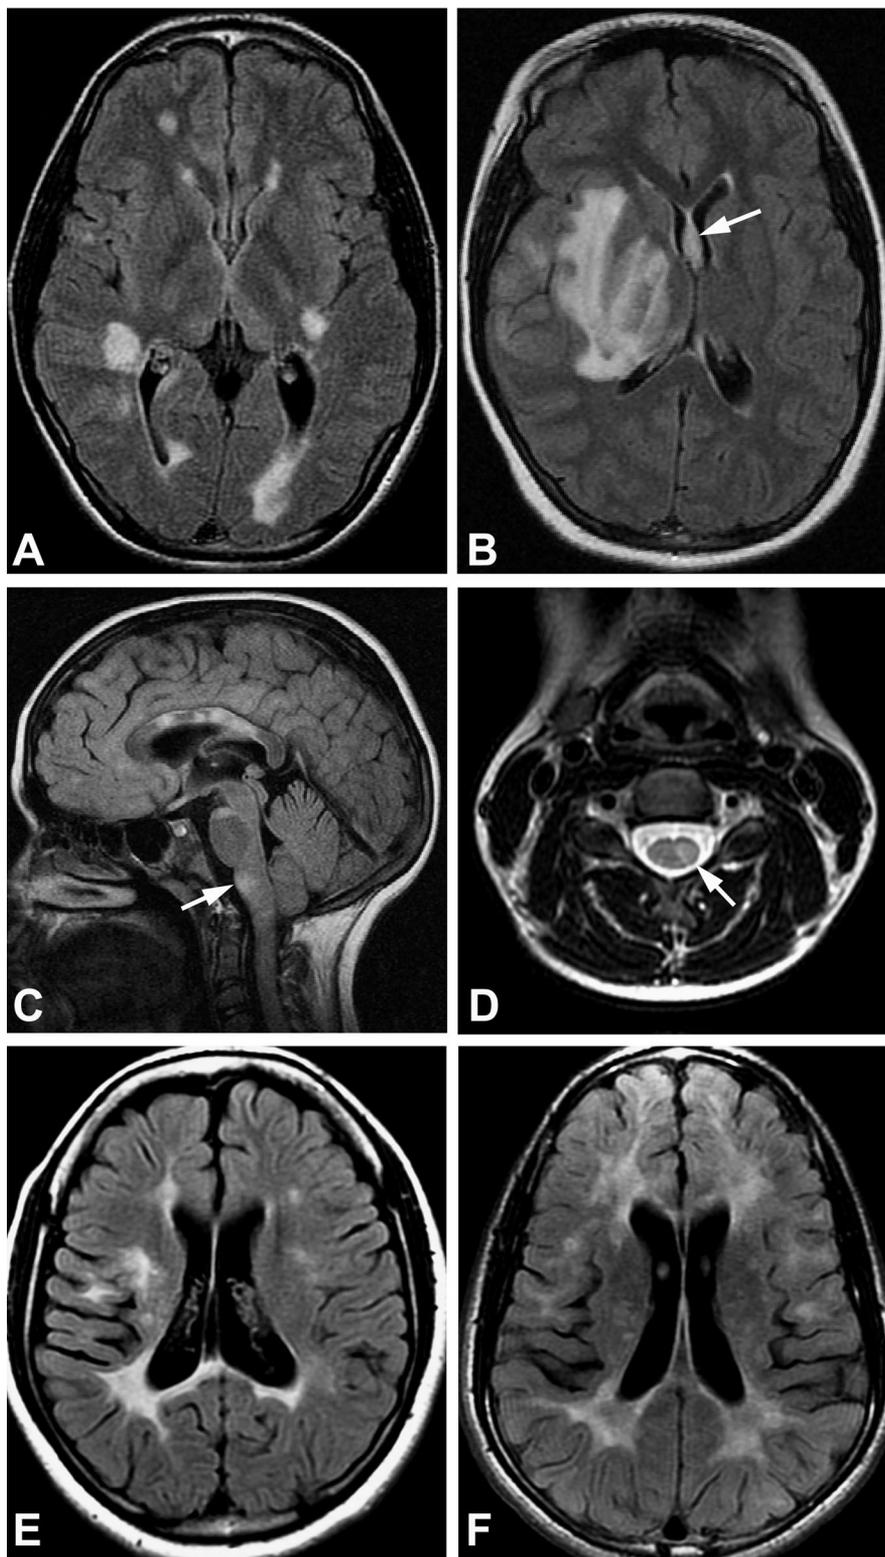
MRI appearance of multiple sclerosis (MS) in children. (A) Axial fluid-attenuated inversion recovery (FLAIR) image of an adolescent patient with MS demonstrating typical ovoid white matter lesions in the periventricular and deep white matter. (B) Axial FLAIR image demonstrating a large lesion involving the deep gray and white matter associated with significant mass effect, consistent with tumefactive demyelination. Note the white matter involvement in the fornix (arrow). The child, an 11-year-old Korean girl, presented with focal seizures and hemiparesis. She had presented with optic neuritis several months prior to the present scan. She has experienced four MS relapses over the last 3 years. (C) Sagittal FLAIR image highlighting multiple lesions within the corpus callosum in a 9-year-old girl with MS. A lesion in the brainstem is also visible. (D) Axial T2 image through the cervical cord demonstrates a hyperintense lesion in the left side of the cord (arrow) at the C4 level. This child, a 15-year-old, presented with hemisensory loss and l'Hermitte symptom. (E, F) Axial FLAIR images of two pediatric-onset patients with MS. The patient represented in E is a 17-year-old adolescent with MS disease duration of 9 years. The patient represented in F is a 14-year-old boy diagnosed with MS for 3 years. He has experienced more than eight clinical relapses and has progressive cognitive impairment. The confluent appearance of the white matter lesions represents coalescence of multiple smaller lesions, as was confirmed on evaluation of their prior MRI studies (not shown).
